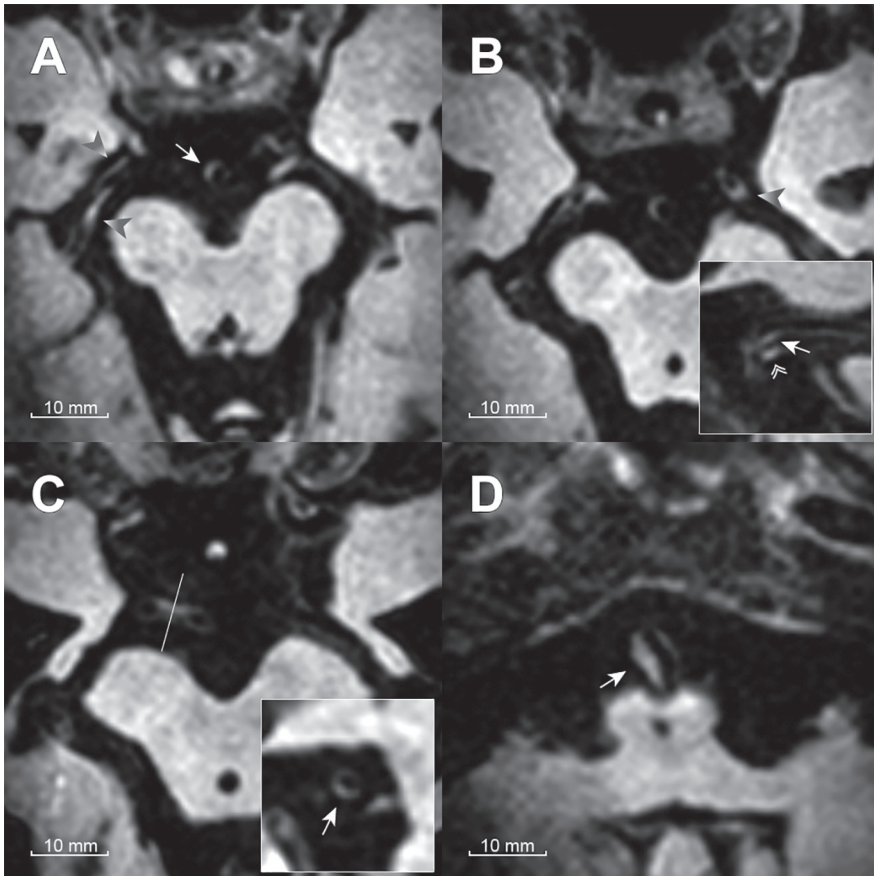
Vessel wall lesions on intracranial vessel wall–MRI at 7T. A) Two lesions (arrowheads) in the lateral and medial wall of the right P2 segment. Compare to normal, barely discernable, mirroring wall. A third lesion is visible in the distal basilar artery (arrow). B) Lesion in inferior wall of P2 segment left (arrowhead). On oblique multiplanar reconstruction angulated to the P2 segment (panel) a slight wall thickening (arrow) is appreciated. Note the passing oculomotor nerve (double arrowhead). C) Lesion in the inferior wall of the right P1 segment, best appreciated on oblique multiplanar reconstruction (arrow). D) Large lesion in the right wall of the proximal basilar artery.
